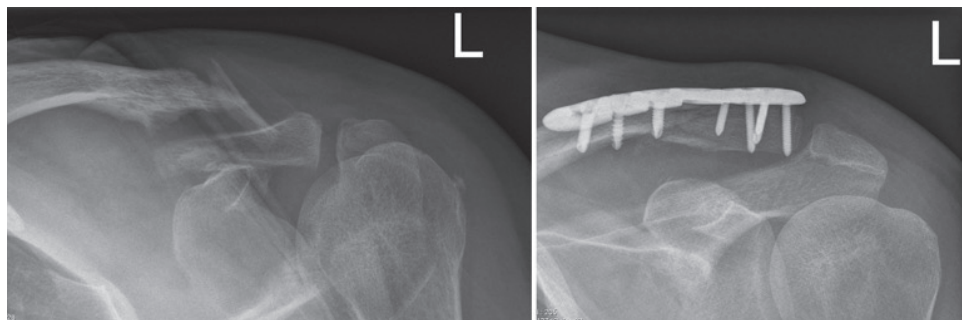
Preoperative radiograph of lateral clavicular fracture and postoperative radiograph after superior clavicle plate with lateral extension (SCPLE) fixation.
